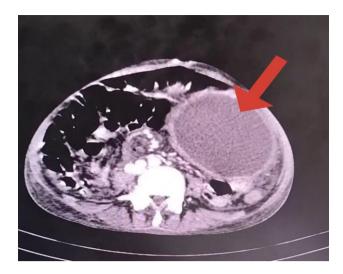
Axial section of contrast enhanced CT abdomen showing pseudocyst.
